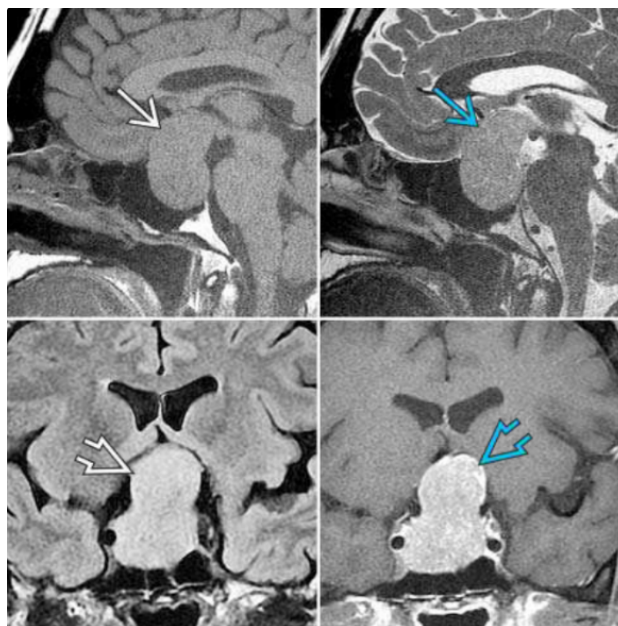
Sagittal MRI showing a sellar and suprasellar mass consistent with a macroadenoma
